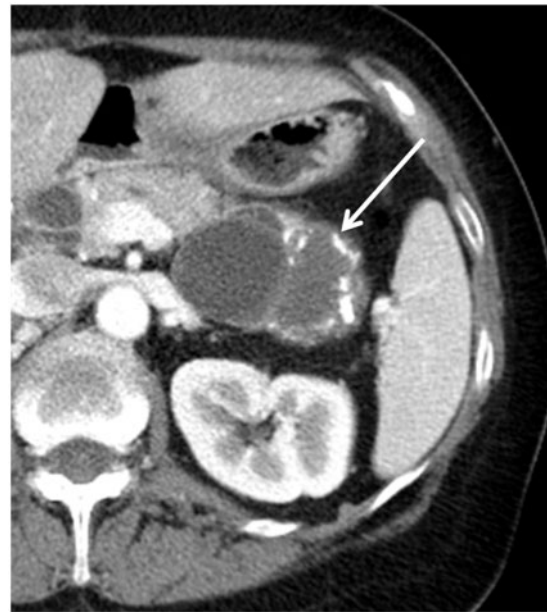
Cystic pancreatic incidentaloma on an MDCT scan performed to evaluate hematuria in a 51-year-old woman. CT shows several septations, areas of minimal mural thickening, and curvilinear calcification within a mass in the pancreatic tail (arrow). A mucinous cystadenocarcinoma was found pathologically.
